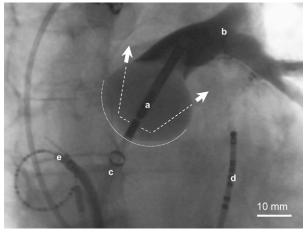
The angiogram of the HIFU catheter balloon in the human heart. (a) The white dashed arrows outline the ultrasound path from cylindrical transducer inside a water-filled balloon and focused by a parabolic reflector interface (dotted line) into a PV atrial ostia (large arrows). (b) Left superior PV highlighted by angiographic contrast injection. (c) Transseptal delivery sheath. (d) Pacing catheter in coronary sinus vein. (e) Electrical mapping lasso catheter. Image is obtained following an institutional review board approved imaging protocol from the Medizinische Klinik Allgemeines Krankenhaus St. Georg in Hamburg, Germany.
